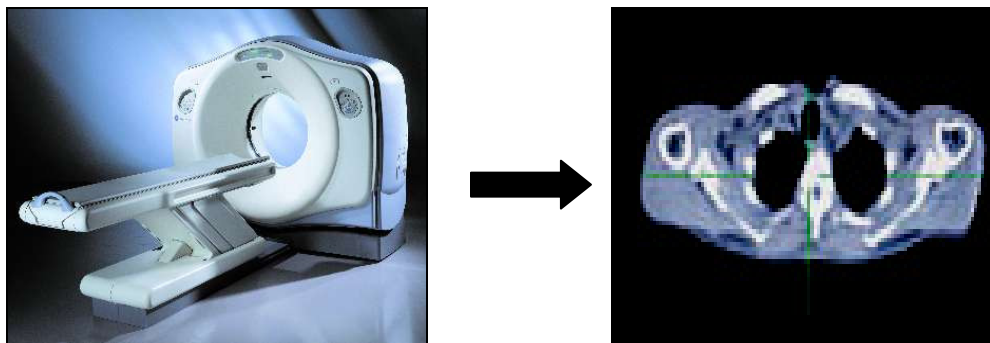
CT scanner on the left and CT transaxial slice (through the lung) on the right (Source: <http://www.wiproge.com/>)
